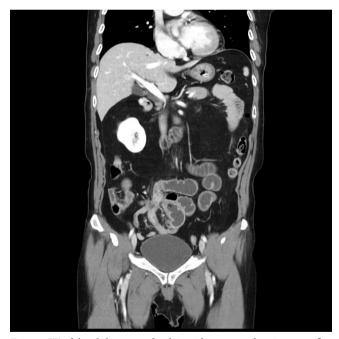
CT of the abdomen and pelvis with contrast showing a confluent fluid-filled small bowel in RLQ and mild wall thickening, surrounding haziness.
